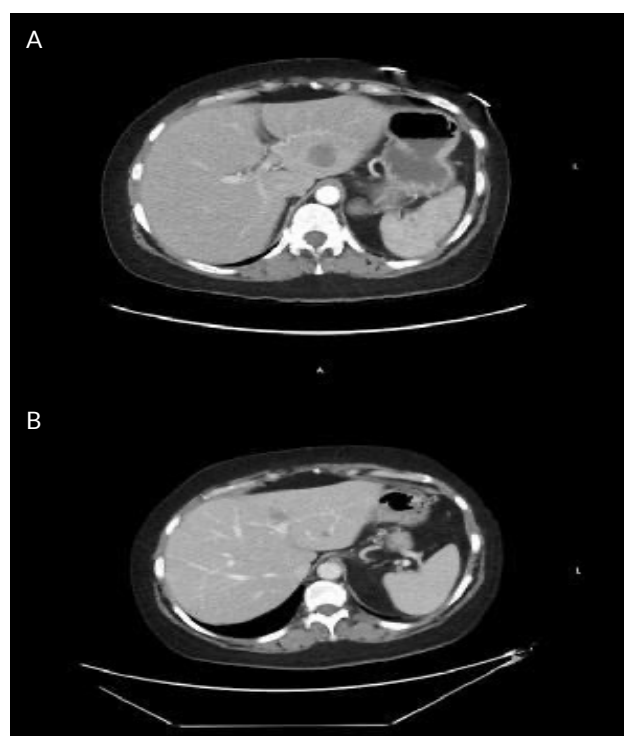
Computed tomography scan of the chest, abdomen, and pelvis. It compares the left hepatic lobe lesion before (A) and after (B) treatment adding carboplatin to the regimen.
